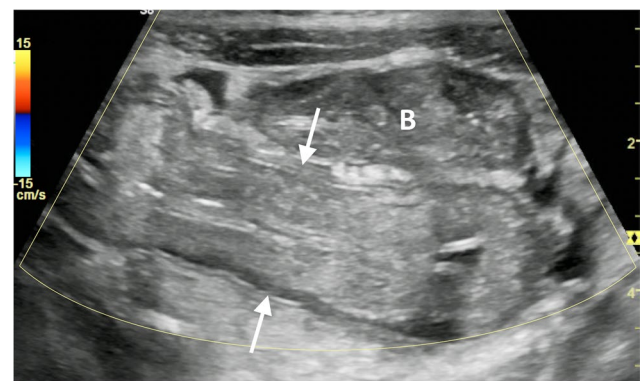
Hemolytic uremic syndrome in a 3-year-old boy presenting with bloody diarrhea, thrombocytopenia and renal failure after eating an undercooked hamburger. Transverse color Doppler US image of the rectosigmoid colon demonstrates marked circumferential mural thickening and partial loss of stratification without associated hypervascularity (arrows) during the initial avascular phase of the disease. Note the bladder (B), which is collapsed in the setting of oliguria
